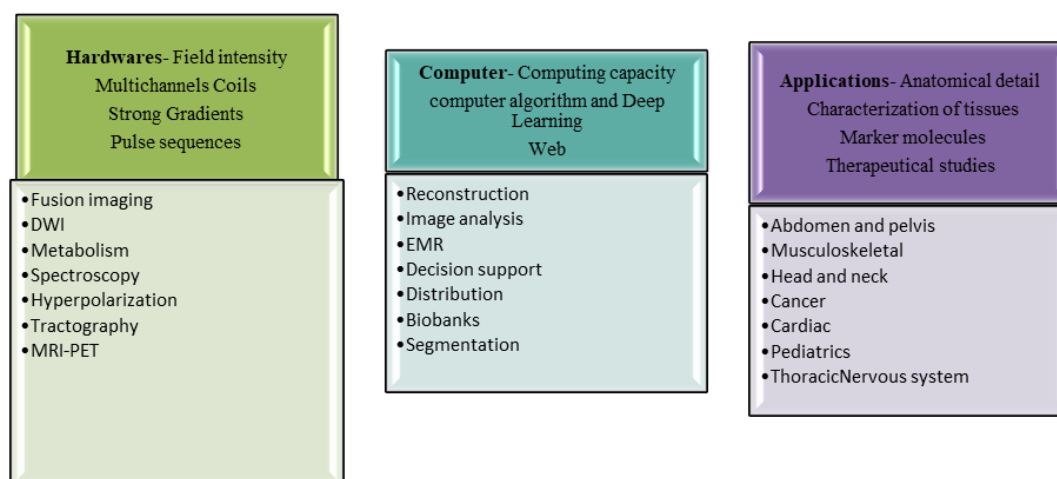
Advancement in MRI technology with a wide range of applications in various fields.
